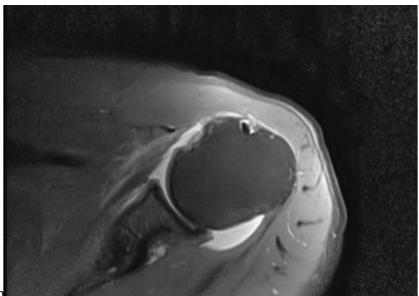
USG shows hypo-echogenicity in the distal supraspinatus Fig 7b. MRI axial PDFS sequences show PDFS hyper intensity of the distal sub-scapularis with mild retraction of fibres
